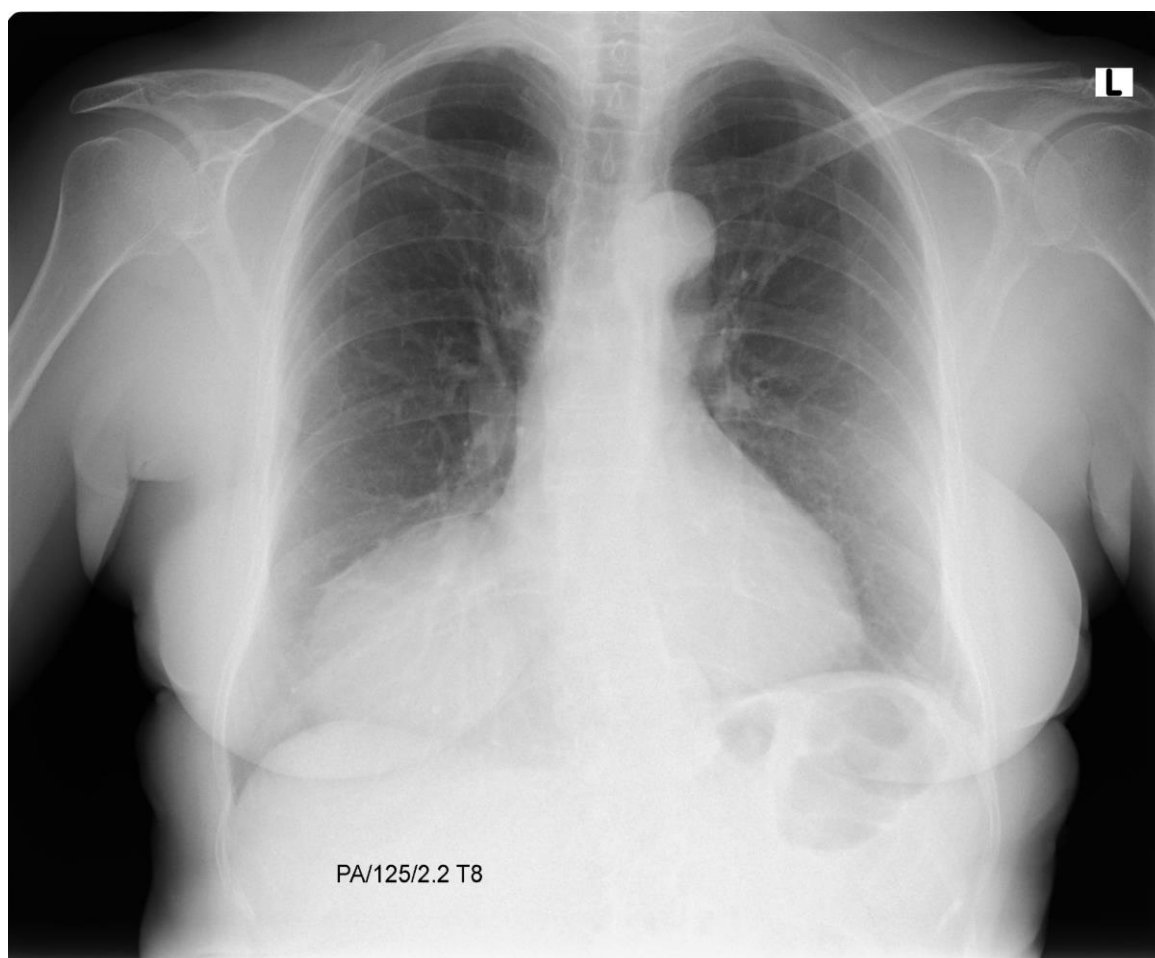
Posterior anterior chest X-ray showing shadowing in the lower right region.
